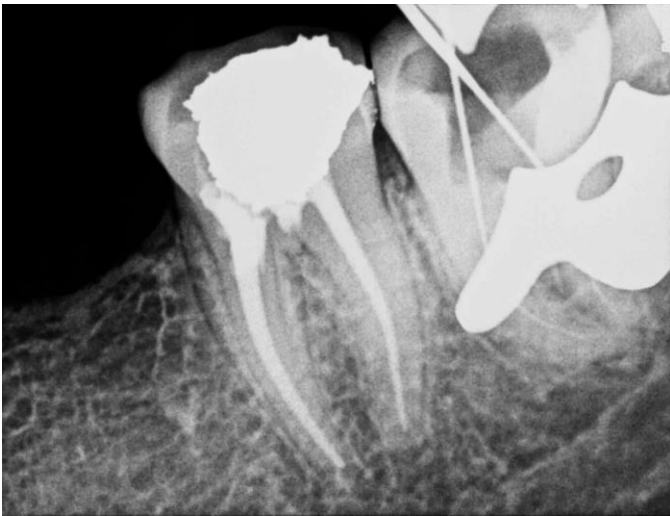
B: Working length Radiograph
